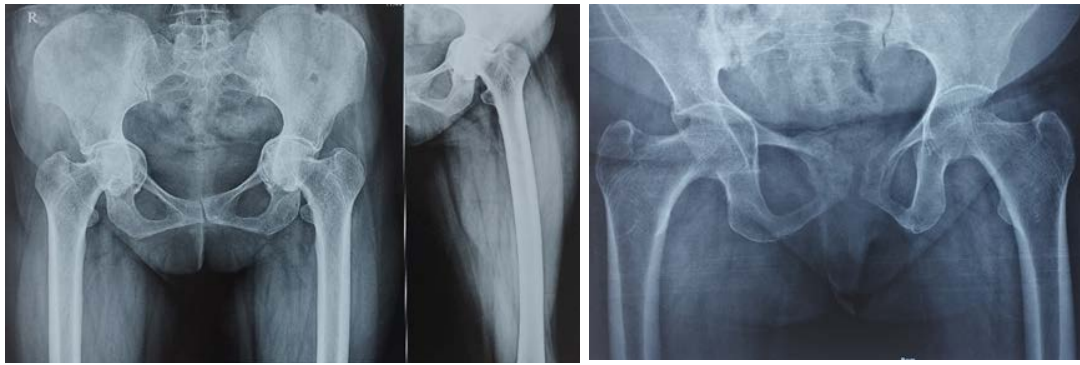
Radiographs of 2 middle aged female patients, 45 and 49 years of age showing painful mixed FAI and advanced osteoarthritis. Common associated etiological factor was housemaid occupation requiring continuous squatting posture. Misdiagnosed and further neglected hip impingement pain when left untreated, overtime reveals its natural course leading to distortion of primary hip anatomy, earlier degenerative osteoarthritis, decrease in neck shaft angle causing coxa vara and eventually protrusio acetabuli.
